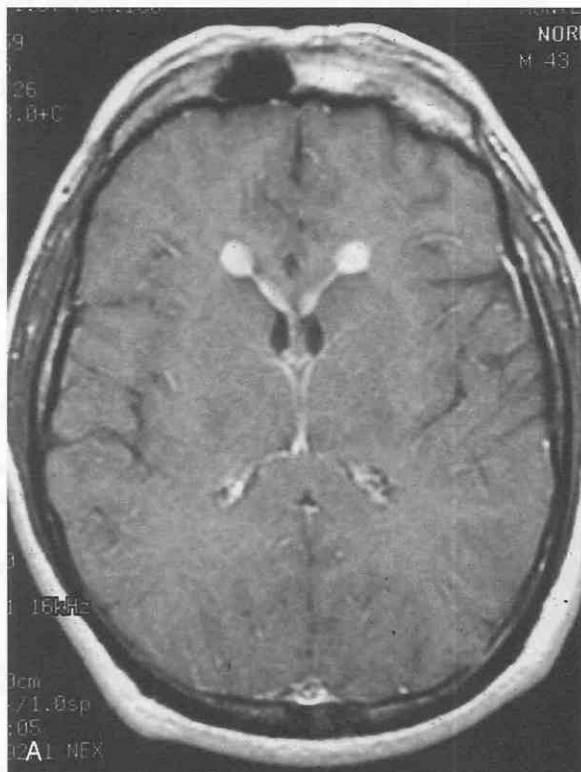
Focal, nodular ependymal enhancement. A, Nodular enhancement of the ependyma of the frontal horns was the probable entry point for subarachnoid spread of melanoma. B, Sagittal T1-weighted image of the lumbar spine shows nodular, enhancing drop metastases to the cauda equina (arrowheads).
